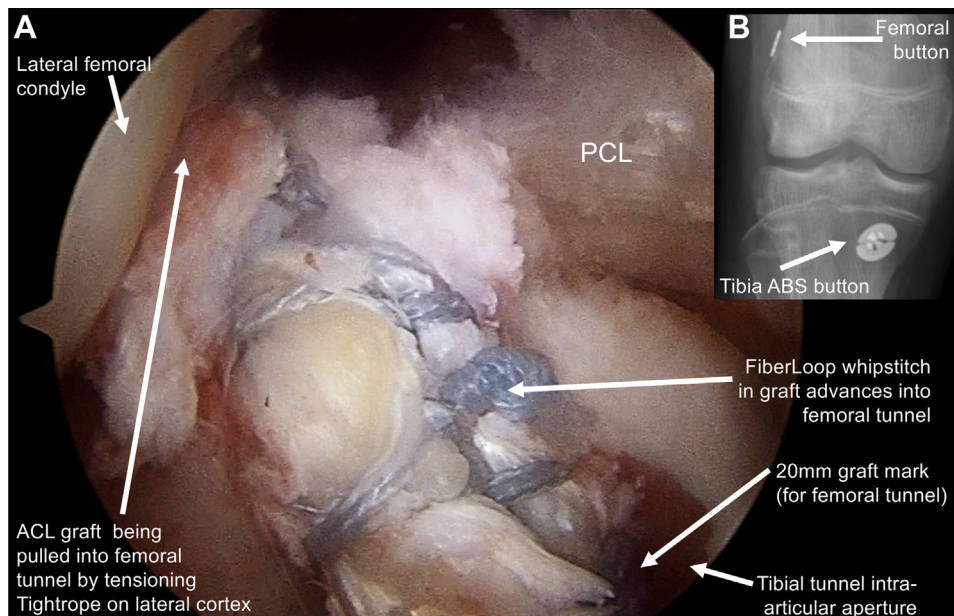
Arthroscopic (A) and anteroposterior radiographic (B) views of a right knee during anterior cruciate ligament (ACL) reconstruction with quadriceps tendon graft. (A) Arthroscopic view from anterolateral portal (the right part of the image is medial). The quadriceps tendon graft is advanced into the femoral tunnel from the tibial tunnel until the 20-mm mark on graft is visible at the entrance to the femoral tunnel (all whipstitch suture is contained in the tunnel). (B) The final anteroposterior radiographic view of a right knee shows appropriate femoral button deployment, tibial ABS button location and fixation, and hybrid transtibial ACL reconstruction tunnels obtained with the described technique. (PCL, posterior cruciate ligament.)
